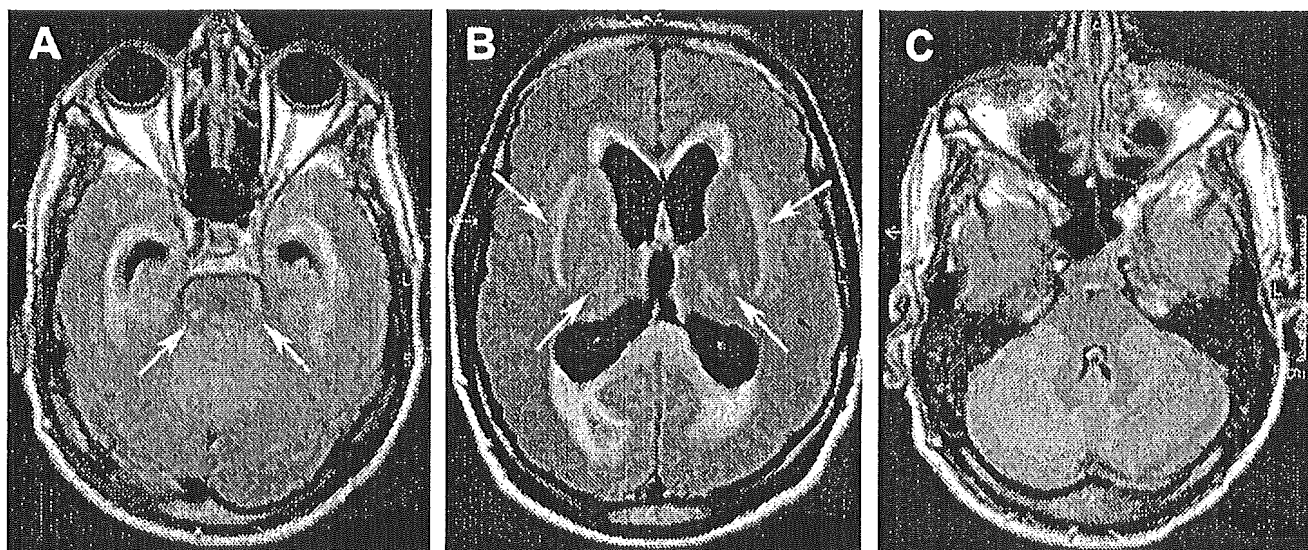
Axial fluid-attenuated inversion recovery MRI of the brain showing hyperintensities in the dorsolateral regions of the pons (A) and bilaterally in the thalamus, globus pallidus, and capsula extrema (B), consistent with osmotic myelinolysis. Also note the enlargement of the lateral and third ventricles with periventricular hyperintensities (B). This acute triventricular hydrocephalus was presumably caused by posterior fossa edema, yielding impaired CSF circulation (C).
